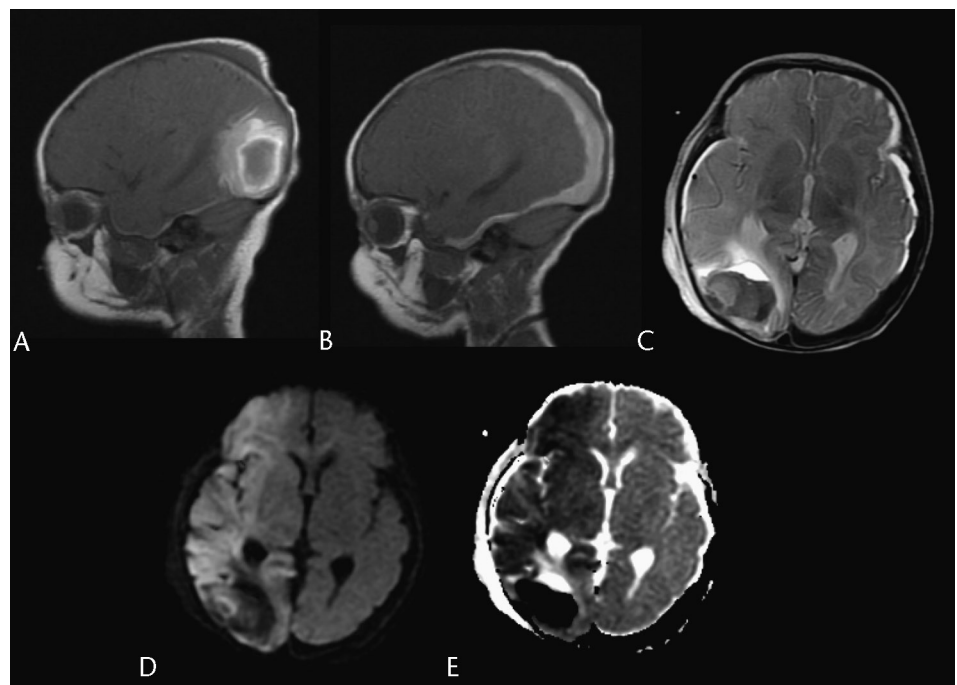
Images obtained from a 1-week-old male neonate who had seizures after delivery at home (no vitamin K administered). After surgical evacuation of large, right-side SDH, sagittal T1 (A, B), axial T2 (C), ADC (D), and DWI (E) images show bilateral mixed-intensity extracerebral and intracerebral hemorrhages and right-side cerebral hemispheric restricted diffusion (likely infarction) (diagnosis, hemorrhagic disease of the newborn [vitamin K deficiency]).
